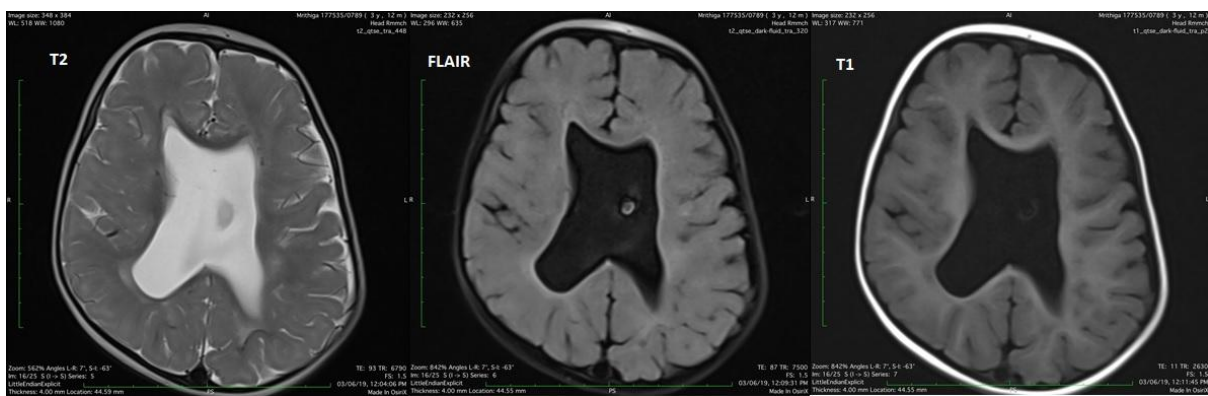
MRI images depicting intraventricular neurocysticercosis with absent septum pellucidum
